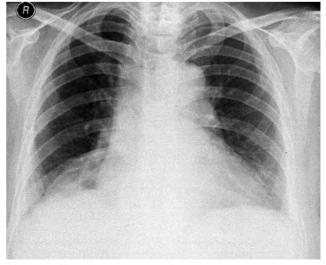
Chest X-ray one month later.
